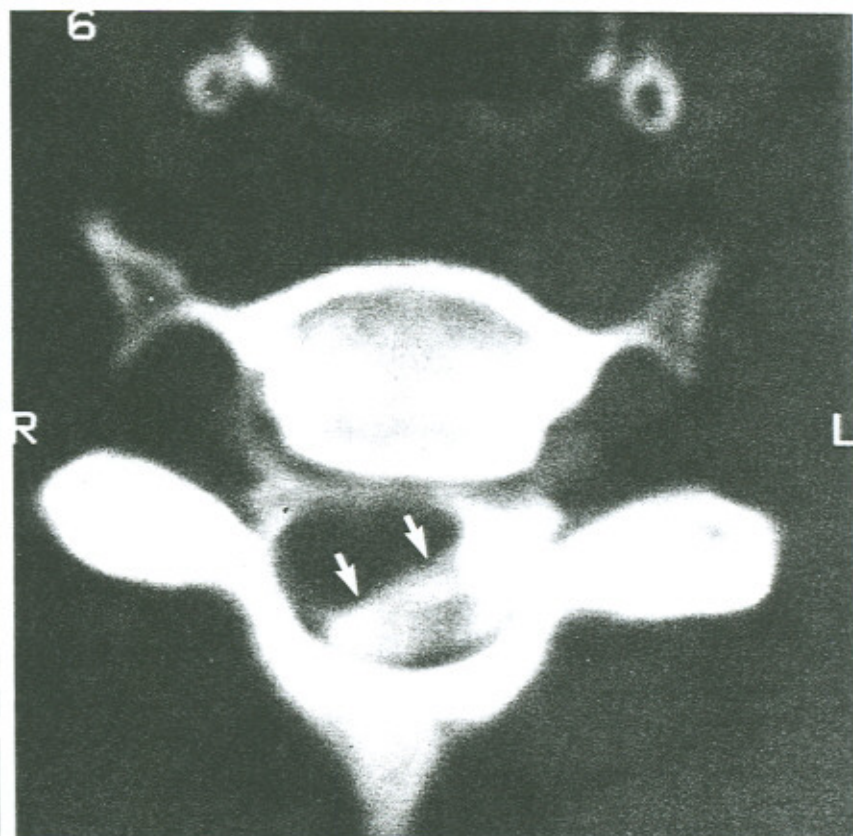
A post-myelogram CT scan at the C7-T1 level outlines a large intradural mass adjacent to the spinal cord and nerve root on the left (arrows).
